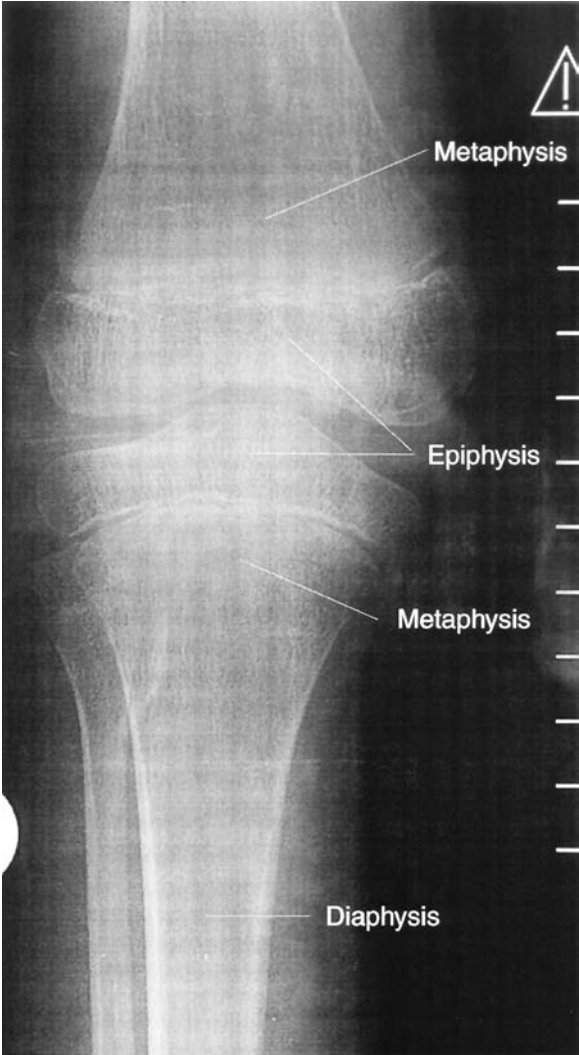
Anteroposterior radiograph of right knee showing epiphysis, metaphysis, and diaphysis.
